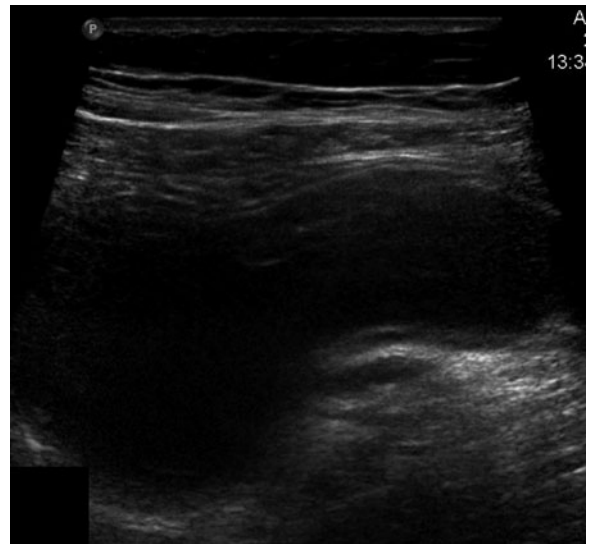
Sonographic appearance of a mucocele of the appendix. US image of the right lower abdomen shows a non-compressible drumstick-shaped cystic structure containing diffuse low-level echoes
